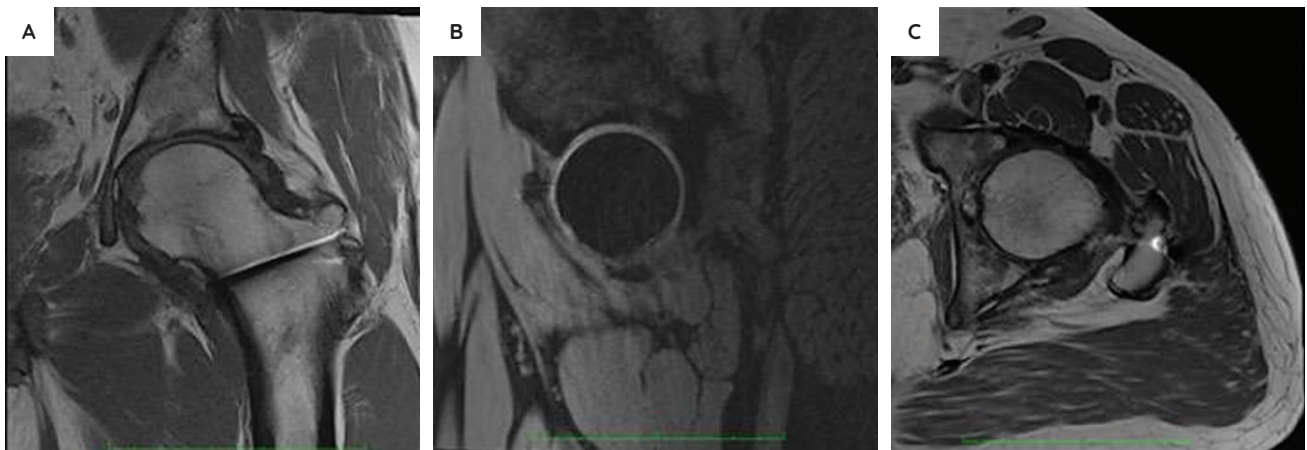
T1-weighted MRI of the pelvis [coronal cut (A)] and axial cuts on T2-weighted (B) and T1-weighted (C) sequences, taken 2 years postoperatively, showing no lysis of the left femoral head and no evidence of avascular necrosis.
